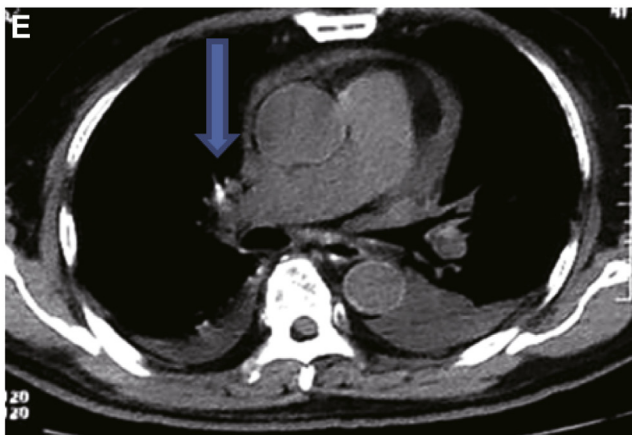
Response to crizotinib in a patient with concomitant MNNG HOS Transforming gene (*MET*) exon 14 mutation and *MET* amplification. Stage IV lung adenocarcinoma was diagnosed in a 76-year-old male never-smoker. A c.2888_2919 deletion, TCTTTCTCTGTTTAA, was identified by next-generation sequencing in *MET* exon 14 in 38.4% of 333 reads (A) in association with moderate mesenchymal-to-epithelial transition factor overexpression (80%++) (B) and *MET* amplification (mean copy number >5.0 per tumor cell (C). A chest computed tomography scan (axial view) is shown before (arrow indicates primary tumor before treatment) (D) and 4 weeks after (E) treatment with the mesenchymal-to-epithelial transition factor inhibitor crizotinib (arrow indicates decreased tumor after treatment).
